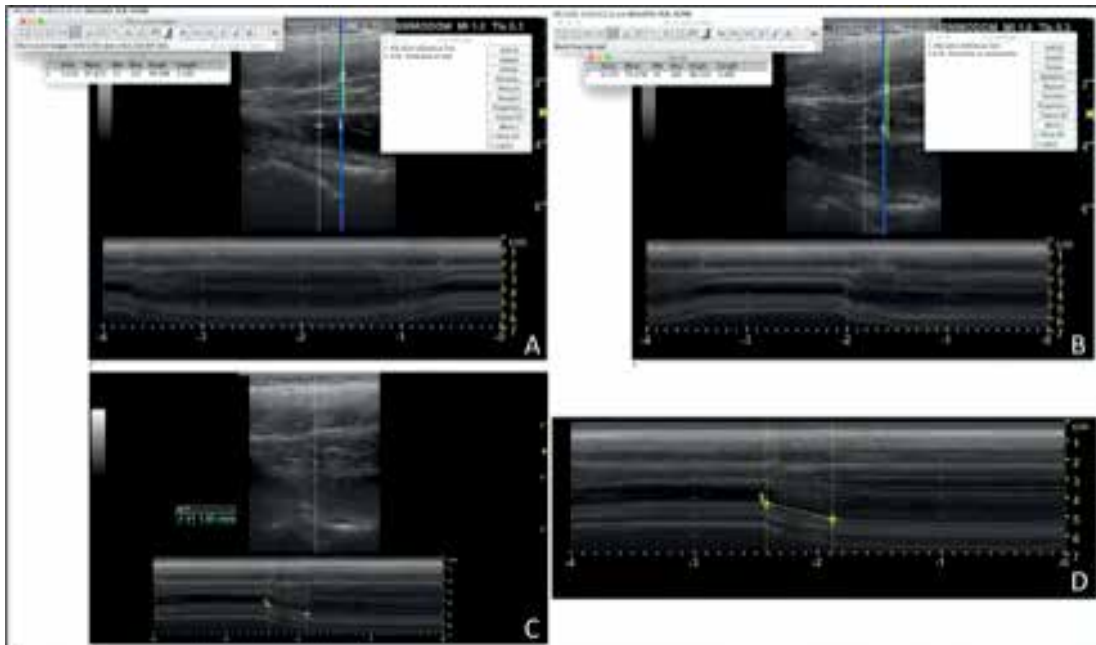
USI measurements for gluteus medius muscle thickness and velocity of contraction. Gluteus medius thickness and velocity of contraction measurements using ImageJ offline software and M-mode ultrasound. Gluteus medius muscle thickness at rest (A) and during muscle contraction (B) using ROI manager tool of ImageJ software (blue line, reference line of hip joint as a measurement point; green line, muscle thickness from inner border of the superficial and deep connective tissue. C – Gluteus medius velocity of contraction using M-mode ultrasonography, D – measuring the latest point of muscle rest state until the first stable point of the muscle contraction phase
